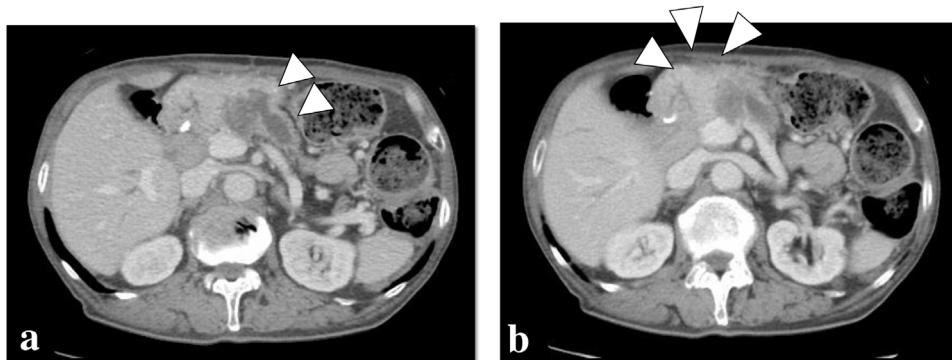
Abdominal contrast-enhanced computed tomography scan.
